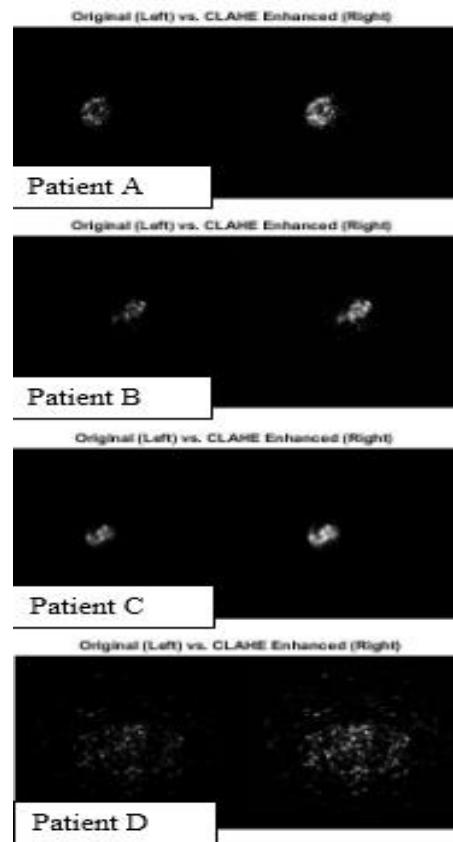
Applying CLAHE to a random CT slices
